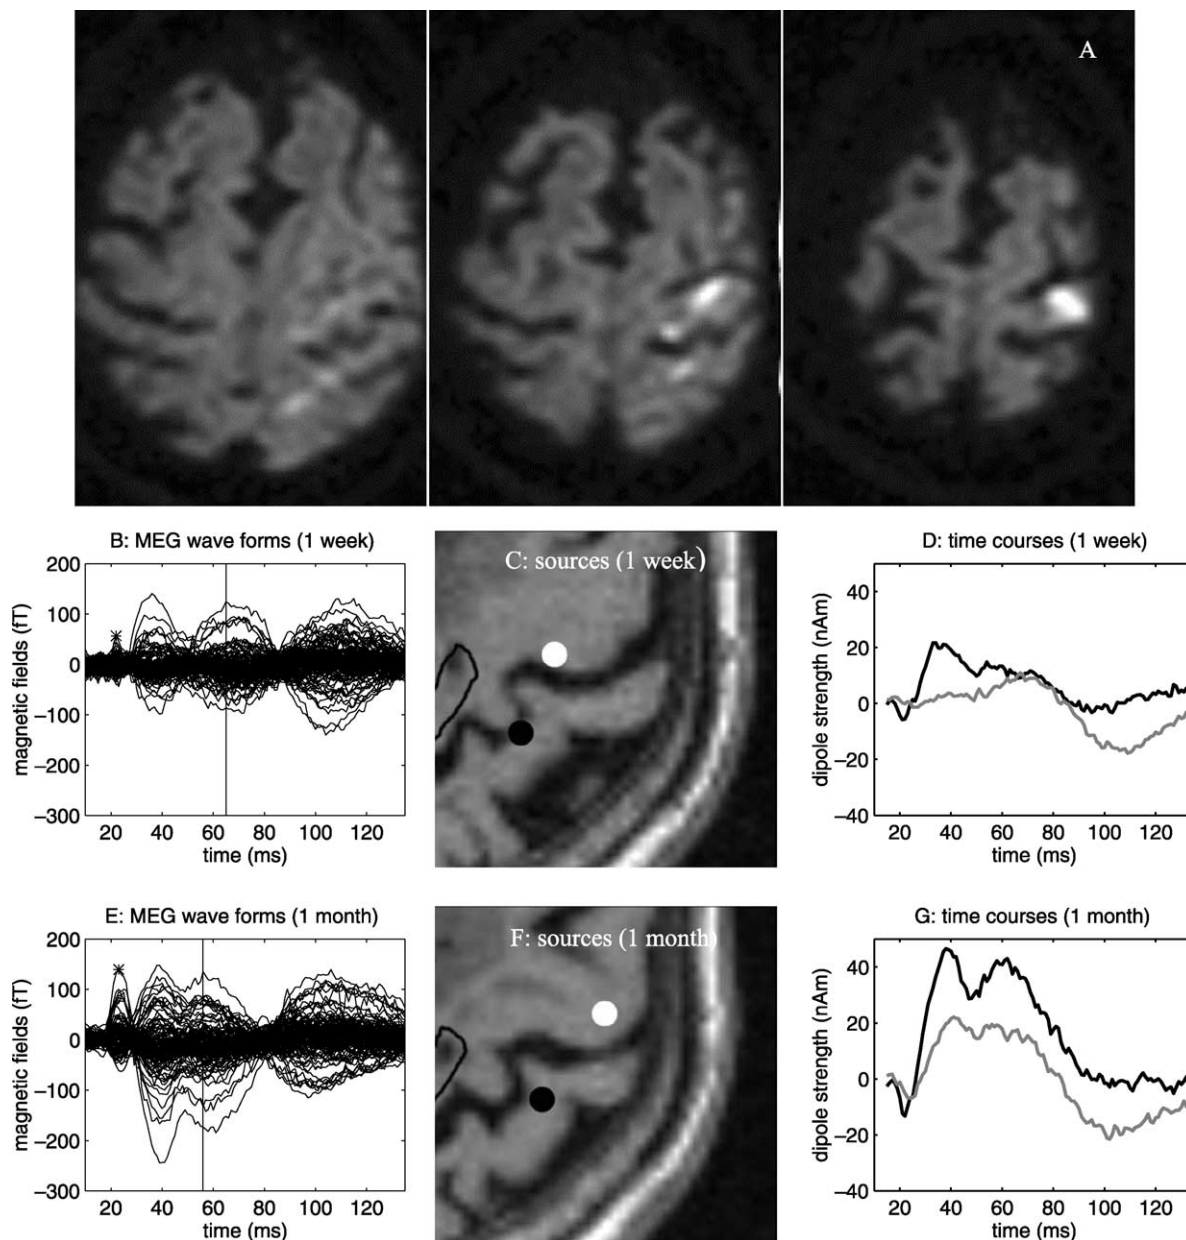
Patient 1. (A) Diffusion-weighted MR images of a stroke patient shows small acute infarcts in the pre- and postcentral gyri. Radiological convention was adopted where the left side of the MR images represents the right hemisphere. (B) MEG averaged signals evoked by median nerve stimulation during the first week of the stroke are superimposed for all 122 channels. (C) SI (black dot) and MI (white dot) sources localized from the first week's median nerve responses are shown in the T1-weighted MR image. (D) The temporal dynamics of the SI (black line) and MI (gray line) sources during the acute stage. Notice that the MI in the first week does not reveal early activity. (E). (F) and (G) show the MEG signal, locations and temporal dynamics, respectively, of the SI and MI sources for the 1-month follow-up. In B and E, the asterisks indicate the peak amplitudes around 20 ms. The boundary of the stroke infarct medial to the MI source is highlighted in C and F.
